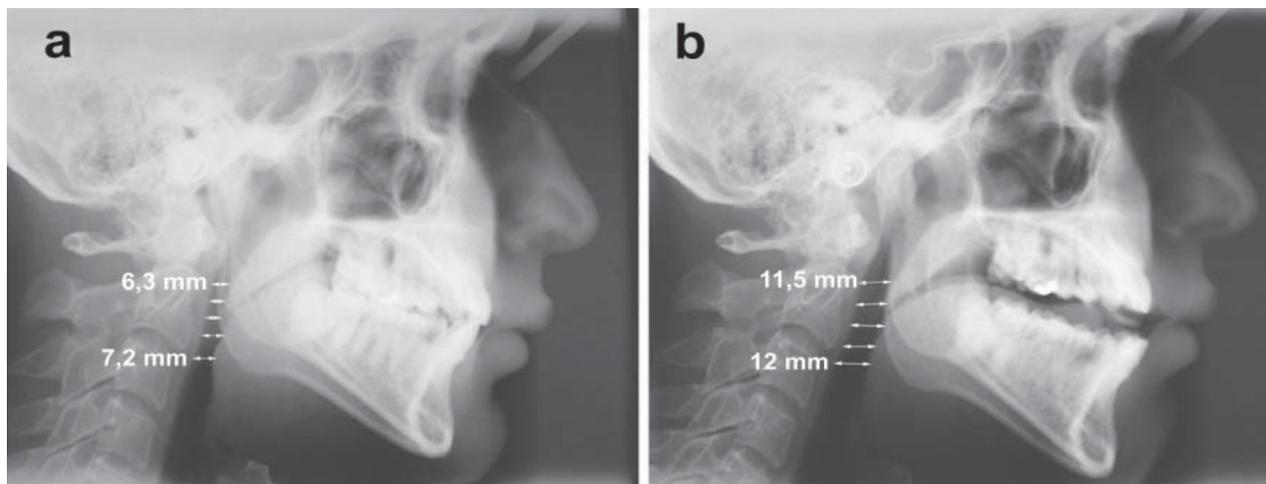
The lateral cephalometric radiograph in the upright position (a) before mandibular advancement appliance, (b) after mandibular advancement appliance.
